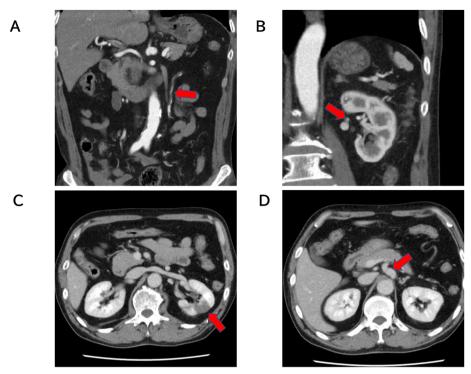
(A) Coronal contrast-enhanced computed tomography (CT) revealed a dissection of the inferior mesenteric artery (IMA) with thrombosis of the false lumen (red arrow) and mild calcification and atherosclerotic changes in the abdominal aorta. (B) Coronal contrast-enhanced CT showing the dissection of the left renal artery with thrombosis of the false lumen (red arrow). (C) The patient had an associated left renal infarction with left renal artery dissection on axial CT (red arrow). (D) Unrelated to the present symptoms, a celiac artery aneurysm was observed on axial contrast-enhanced CT (red arrow). No stenosis was found at the origin of the celiac artery.
